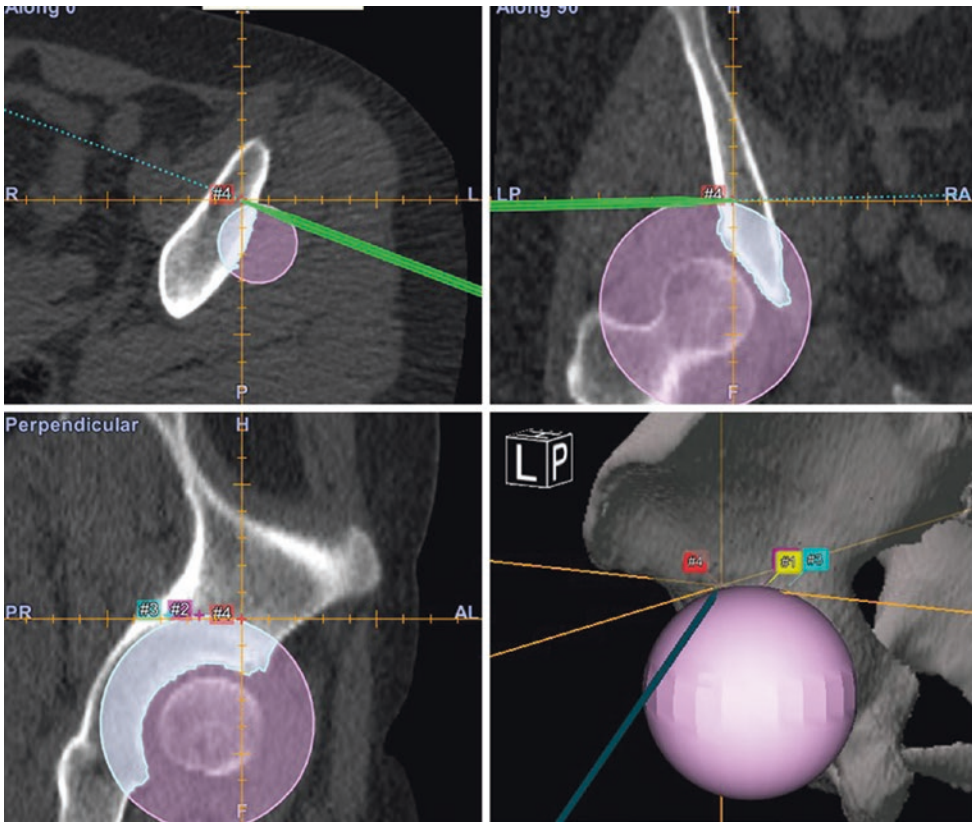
The navigation monitor displays the position and direction of the osteotome tip on the three orthogonal CT reconstructed views and 3D view with the osteotomy plan
